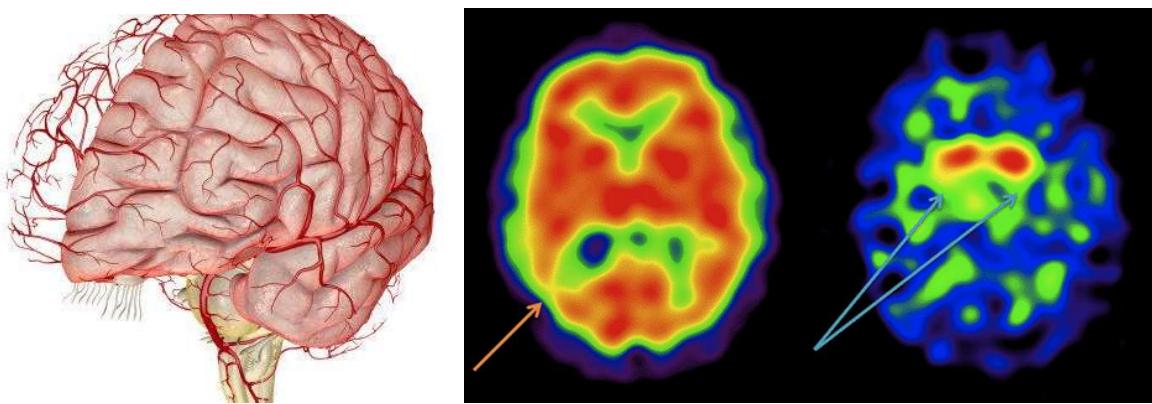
Brain imaging using SPECT: imaging identifies blood circulation in brain and its malfunction.
